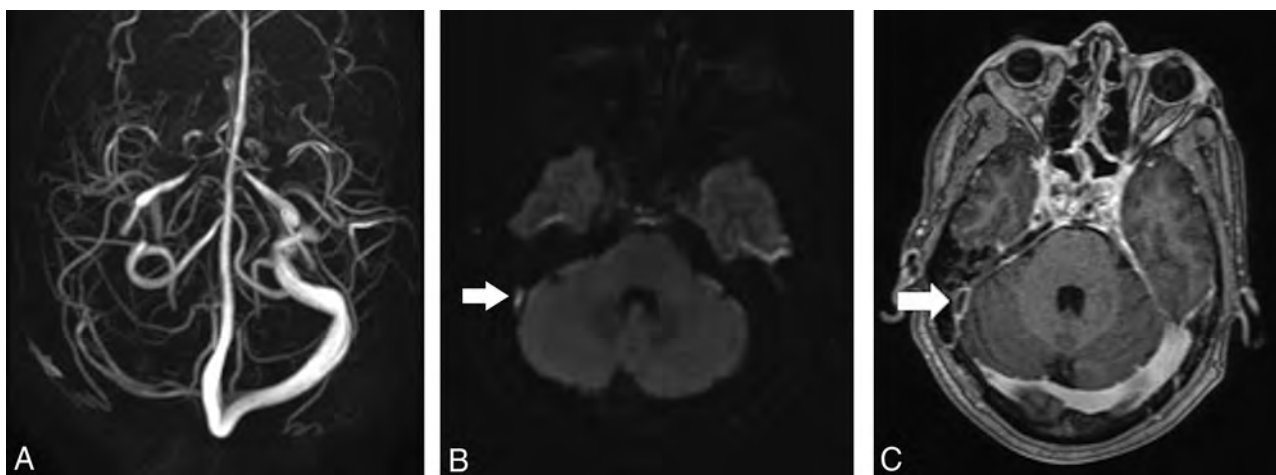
Representative images of a patient different from the one in Fig 3, demonstrating DWI hyperintense signal. Absence of the right transverse and sigmoid sinuses on PC-MRV (A), with associated hyperintense signal on DWI (B, arrow), corresponding to a filling defect on axial MPRAGE (C, arrow).
